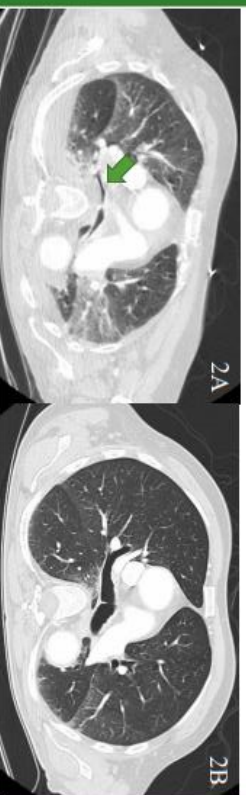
Transverse cut of CT chest (Lung Window) noting airway narrowing extending down to main bronchi. Figure 2B- Same approximate cut of same patient four years prior.
